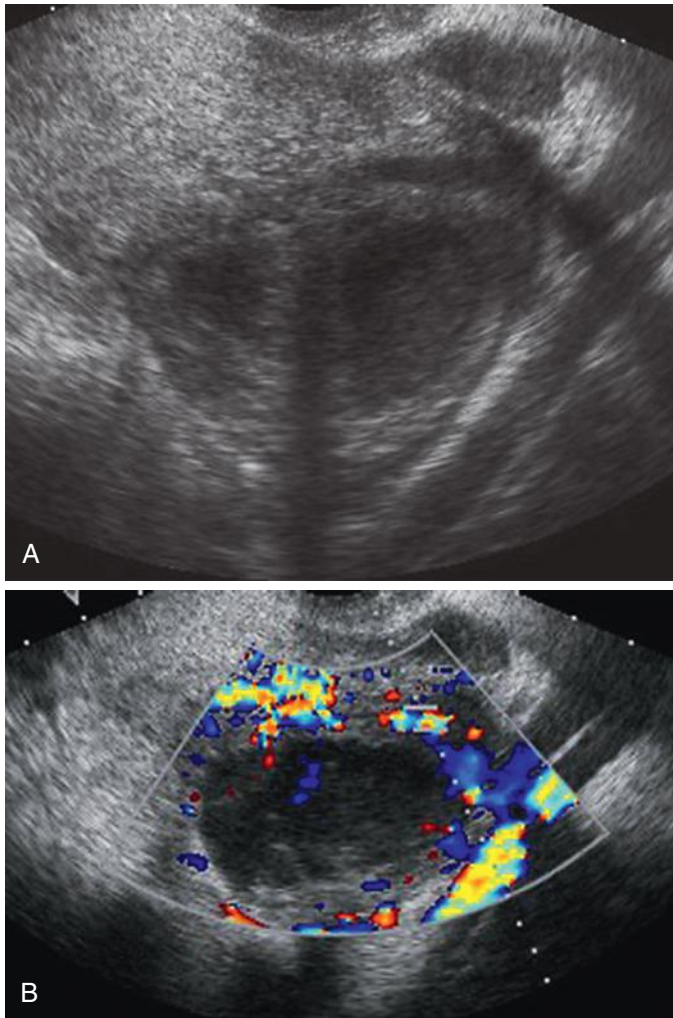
Tubo-ovarian abscess. Gray-scale (A) and color Doppler (B) transvaginal sonographic images of left adnexal cystic mass with internal echoes and marked peripheral vascularity.
